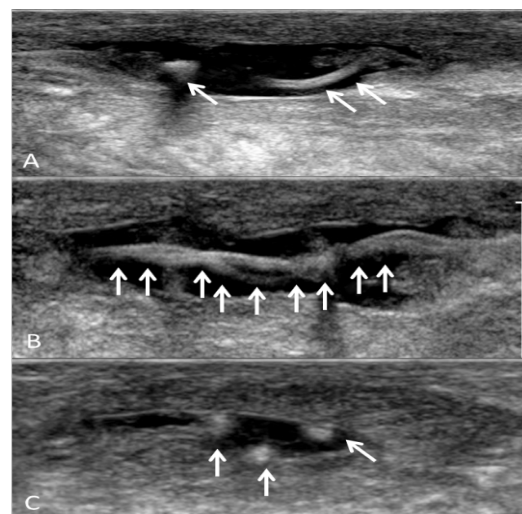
Longitudinal (A, B) and transverse (C) gray scale ultrasound images of the Achilles tendon in patient 2 demonstrate an irregular-walled cystic structure within the Achilles tendon which contains linear, hyperechoic, looped material, consistent with encysted, longitudinally-oriented, sutures within the tendon substance.
